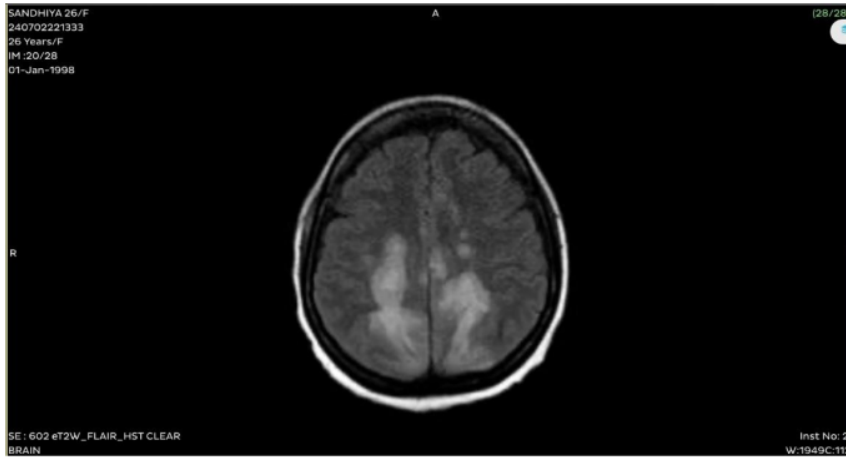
MRI BRAIN – T2W FLAIR
